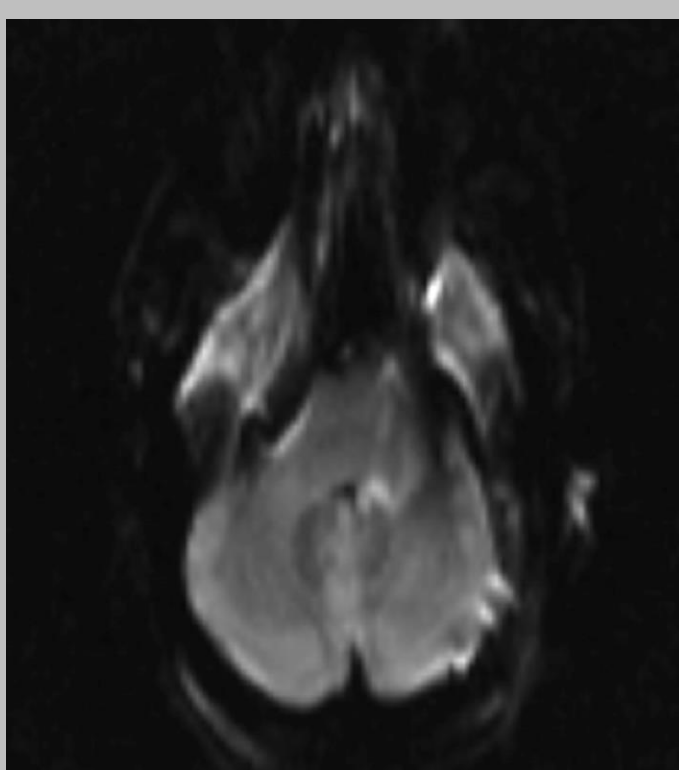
Postoperative DWI
